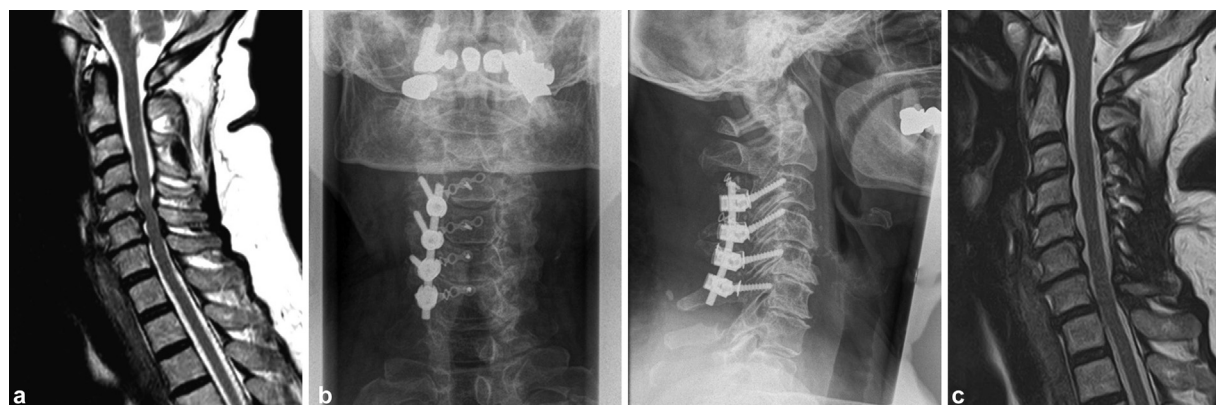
Clinical case of unilateral laminoplasty and stabilization in a 63-year-old male patient, with multisegmental degenerative cervical myelopathy. The preoperative modified Japanese Orthopaedic Association (mJOA) score was 12/17, whereas the postoperative mJOA was 16/17. (a) Preoperative sagittal T2 magnetic resonance imaging (MRI). (b) Postoperative anteroposterior (left) and sagittal (right) X-rays. (c) Postoperative sagittal T2 MRI.
